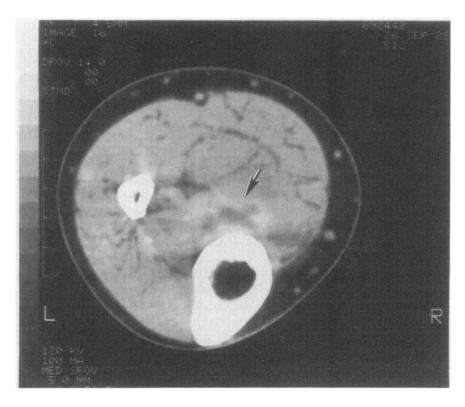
Parenteral contrast-enhanced CT scan of left gastrocnemius of Patient 1 demonstrating area of pyomyositis (arrow indicates site of lesion).
